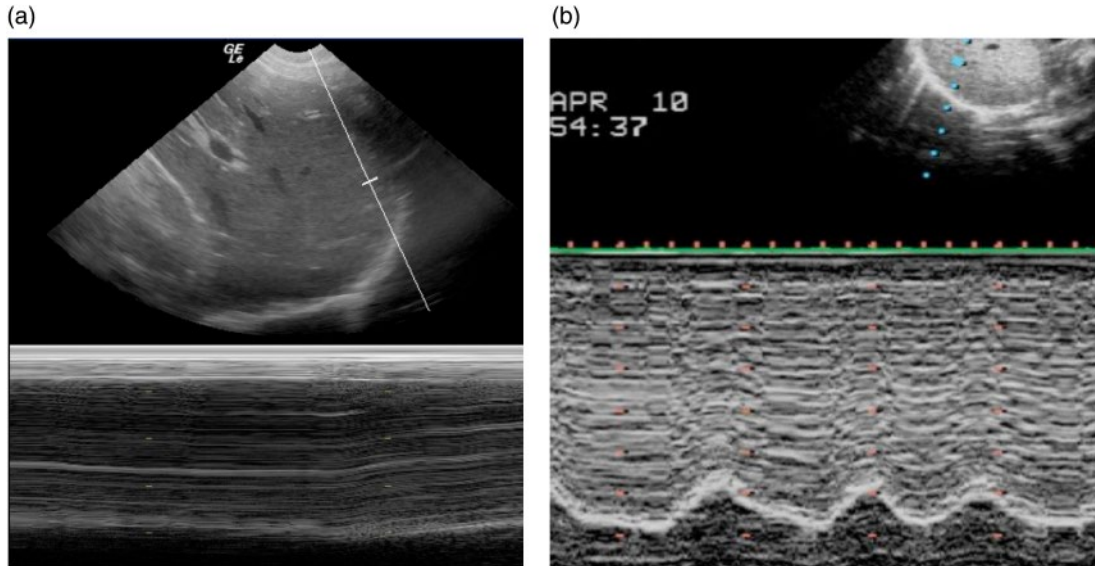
The use of M-mode ultrasound for diaphragmatic motion assessment. (a) M-mode placed through diaphragm showing no motion. (b) M-mode showing motion of the diaphragm.
